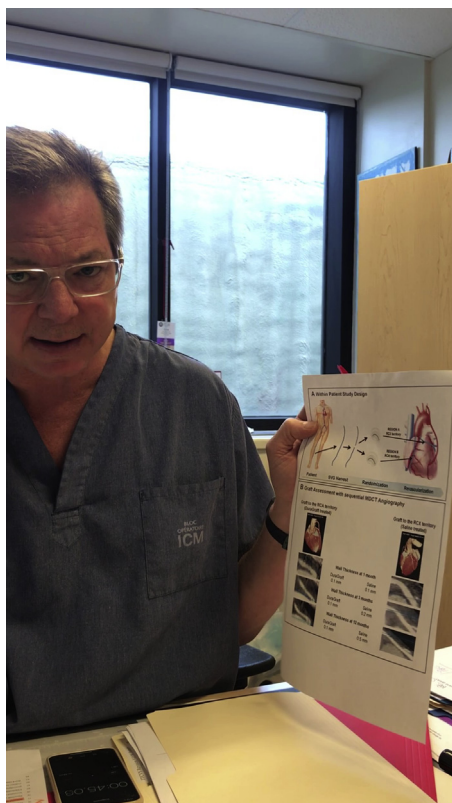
Study design and main findings. A, Using a within-patient study design, from each patient the saphenous vein was harvested and divided into 2 segments before these were randomized to treatment with DuraGraft (Somahlution, Jupiter, Fla) or saline stratified for anastomosis to target region A (right circumflex [RCX] or diagonal or other) or target region B (right coronary [RCA] system or diagonal or other) and use of the proximal or the distal segments of the harvested graft. B, After coronary artery bypass graft, sequential multidetector computed tomography (MDCT) angiography imaging was performed at 4 to 6 weeks, 3 months, and 12 months, respectively. Representative imagery from a patient showing an DuraGraft-treated saphenous vein graft [SVG] to the RCA territory (*left panel*) and a SVG to the RCX territory treated with saline (*right panel*). Wall thickness is calculated from graft filled with contrast (shown) to determine lumen diameter and images without contrast (not shown) to determine vessel diameter. There was an unchanged mean wall thickness in the DuraGraft-treated graft; the mean wall thickness in the saline treated graft increased over time. C, Main study findings showed that DuraGraft-treated SVGs had a lesser mean wall thickness at 12 months compared to saline-treated grafts.
